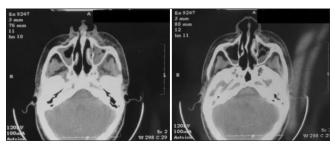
CT PNS image showing bilateral maxillary sinus involvement
